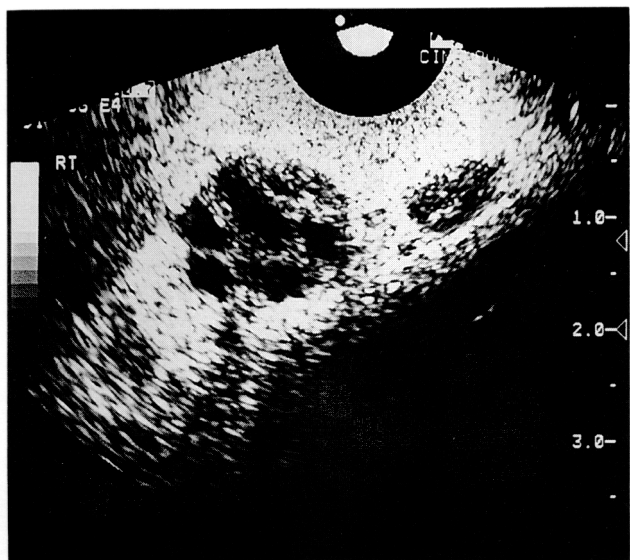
Transrectal ultrasonography showed focal hypoechoic lesion in both peripheral zone of peripheral gland suggesting prostate cancer.
